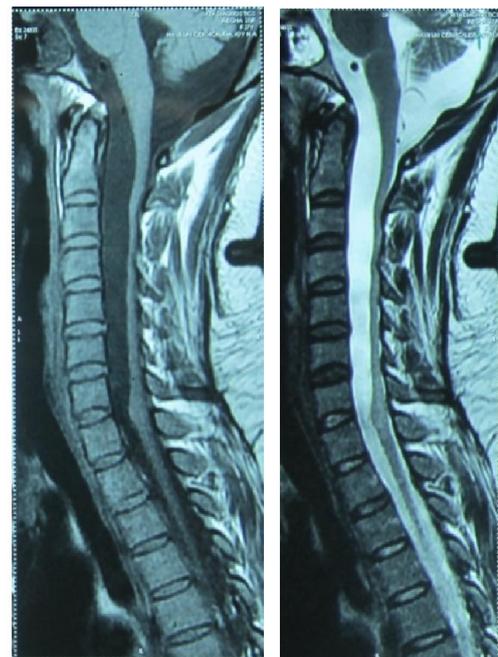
MRI T1 and T2W sagittal images showing the extent of lesion from ponto-medullary junction to C7
